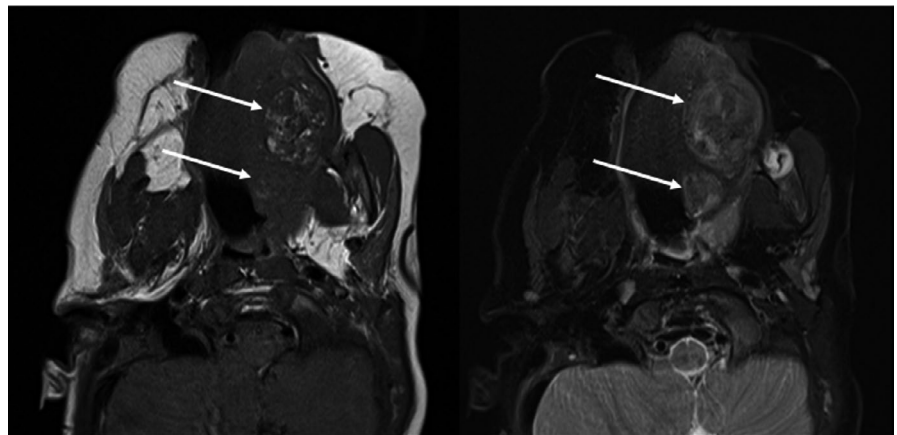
MRI images of floor of mouth lesion. Axial T1 pre-contrast image (left) shows the floor of mouth lesion with internal bright fat signal pre-contrast that matches subcutaneous fat signal. Axial T1 fat saturation (FS) post-contrast image (center) show the fat signal as dark, again matching the subcutaneous fat signal. Note how the non-fatty internal soft tissue enhances post-contrast. Axial T2 FS image (right) shows internal fat signal as dark, matching the subcutaneous fat, while the non-fatty internal tissue is very T2 bright
